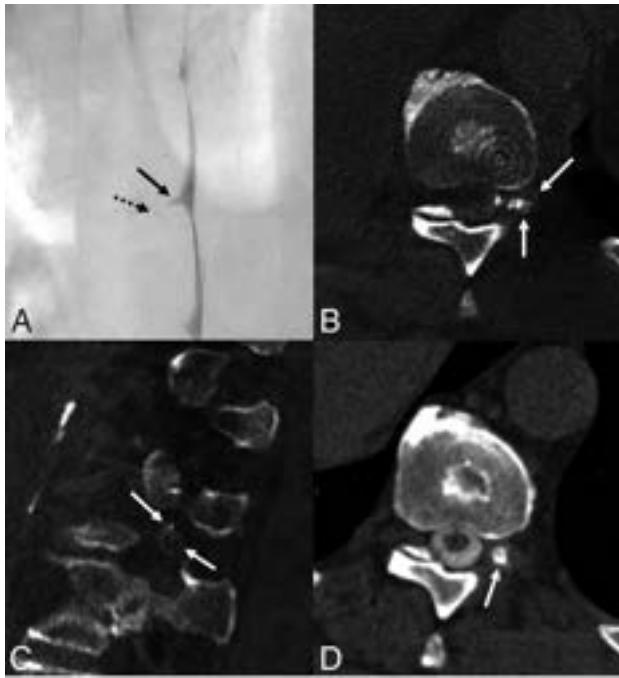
A 66-year-old man with many years of orthostatic headaches that improved after surgical treatment of a left T10 CSF-venous fistula and then recurred. Left lateral decubitus DSM (A) shows a mildly prominent left T10 meningeal diverticulum (A, arrow), with no definite venous contrast on dynamic imaging. Minimal hyperdensity seen adjacent to the diverticulum (A, dashed arrow) was initially thought to be artifactual, secondary to motion or a multilobed diverticulum. CBCT was performed to further investigate the finding. Axial (B) and sagittal (C) images from CBCT obtained during contrast injection demonstrate opacification of numerous left T10 foramina (B and C, arrows), compatible with CSF-venous fistula. Axial 50-keV reconstruction from a delayed left lateral decubitus CT obtained 20 minutes later (D) shows a prominent left T10 meningeal diverticulum (D, arrow) without convincing venous contrast. The patient was treated with transvenous Onyx embolization of the left T10 fistula, with complete resolution of symptoms in 3 months.
